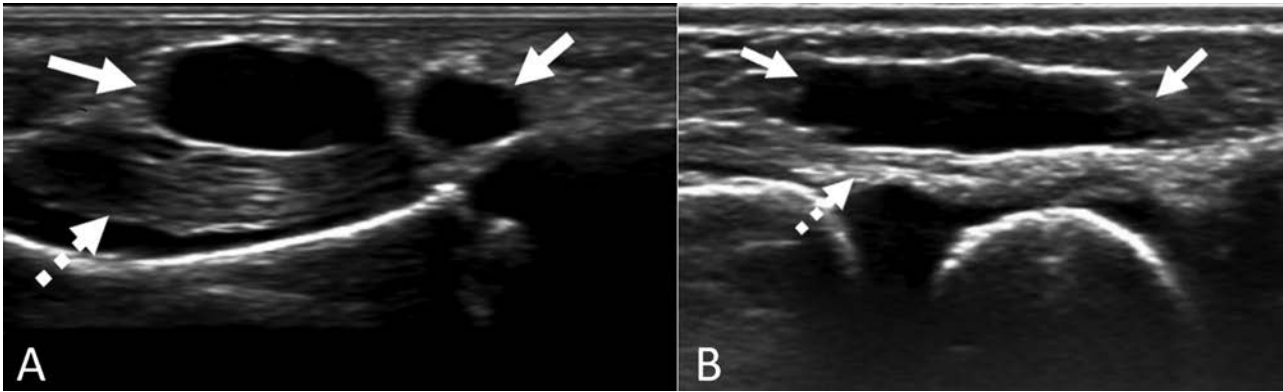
Images from bilateral wrist and hand ultrasound. (A) There is a bilobed 10-mm simple cystic lesion (solid arrow) in the palmar aspect of the left hand along the 5th flexor tendon (dashed arrow). (B) In the dorsal aspect of the right wrist, there is a 17-mm cystic lesion (solid arrow) along the extensor tendons (dashed arrow). Both these lesions were confirmed on a second plane. Similar, multiple lesions were present (not shown).
